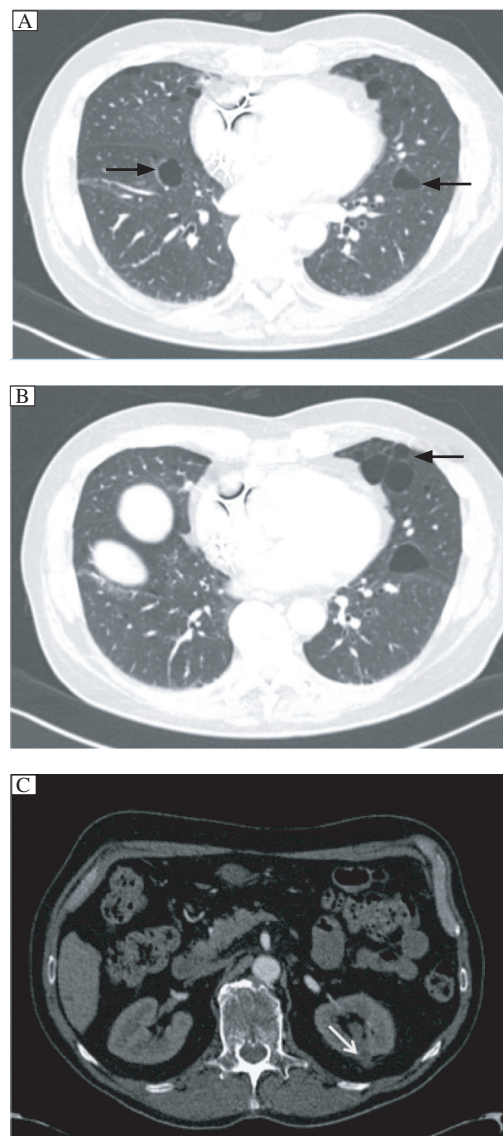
CT results of the case. A: Asymmetric, thin-walled cysts (indicated by arrows) on both bases of the patient's lungs. B: Some of the cysts (arrow) are sub-pleural. C: A left renal cyst is noted on an abdominal CT scan (arrow).
